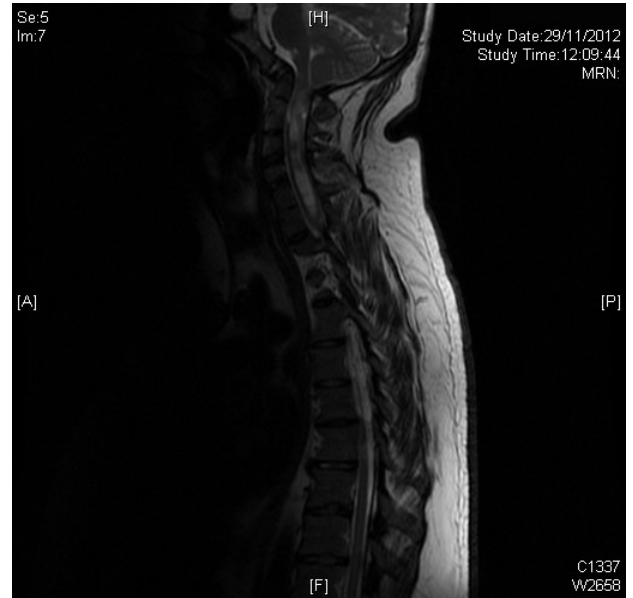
MRI scan showing the syrinx within the cervical spinal canal and vertebral fusion
